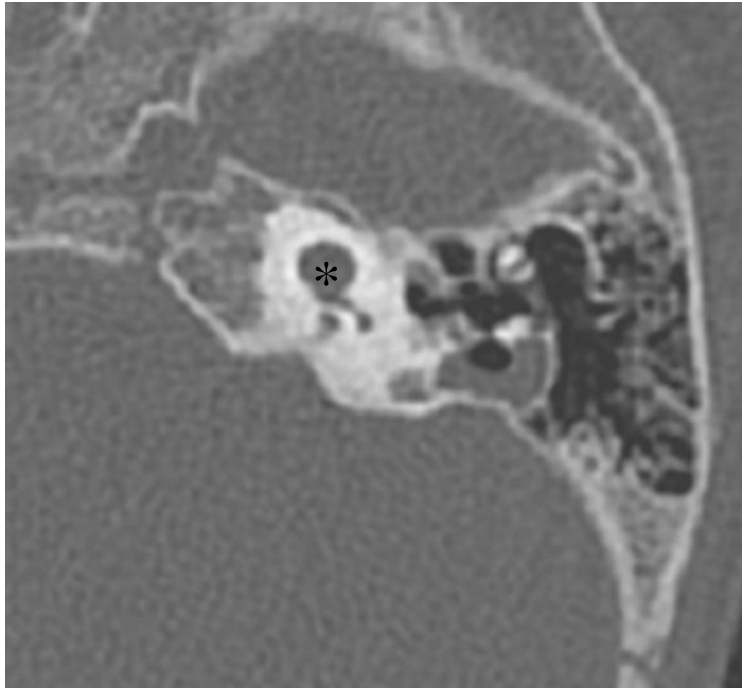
Temporal bone CT scan - Axial and coronal images: a), c), d), normal ear; b) hypoplastic/cystic cochlea, modiolus absent, anomalous facial nerve course, absence of the vestibular system; c) malformed and dislocated ossicular chain, cochlear malformation (hypoplasia); f) g) absent semicircular canals.
